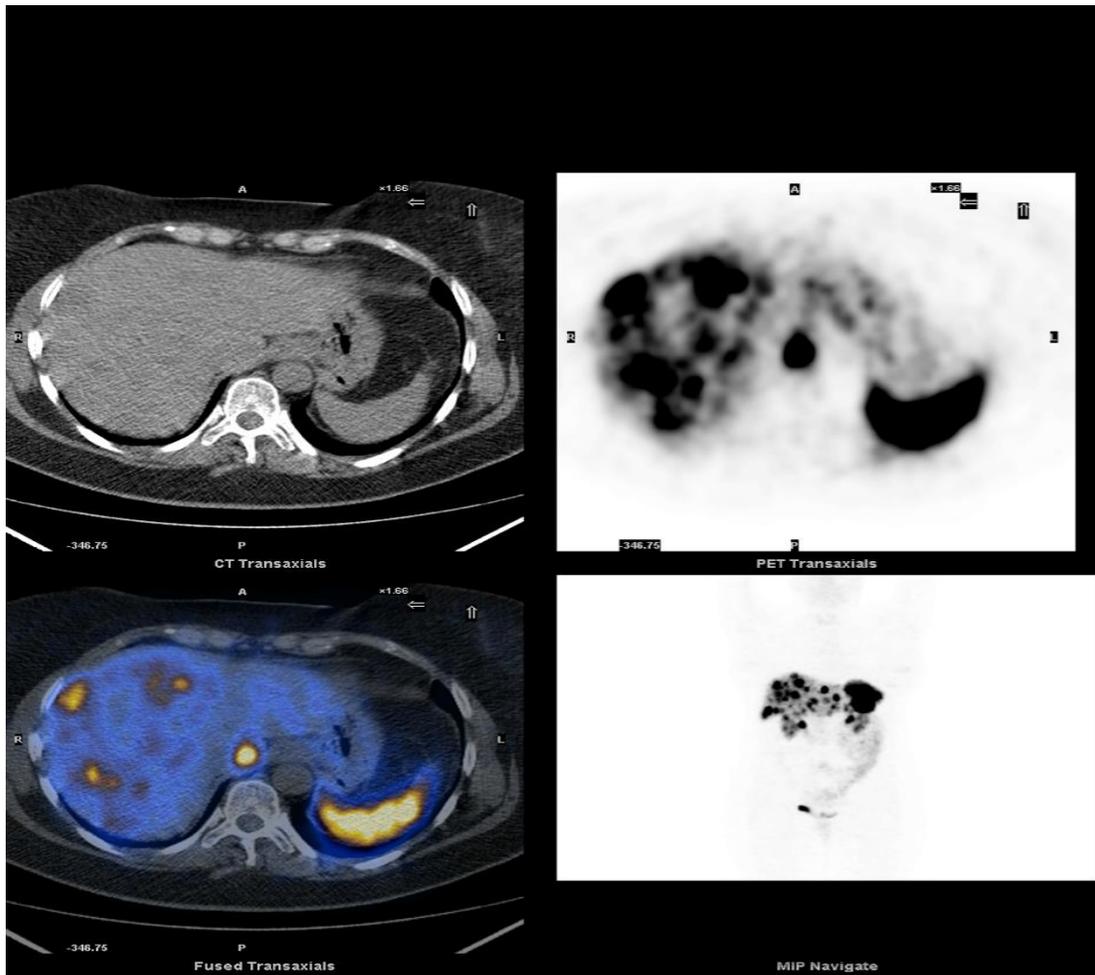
^{68}Ga PET/CT of a pNET with liver metastases
